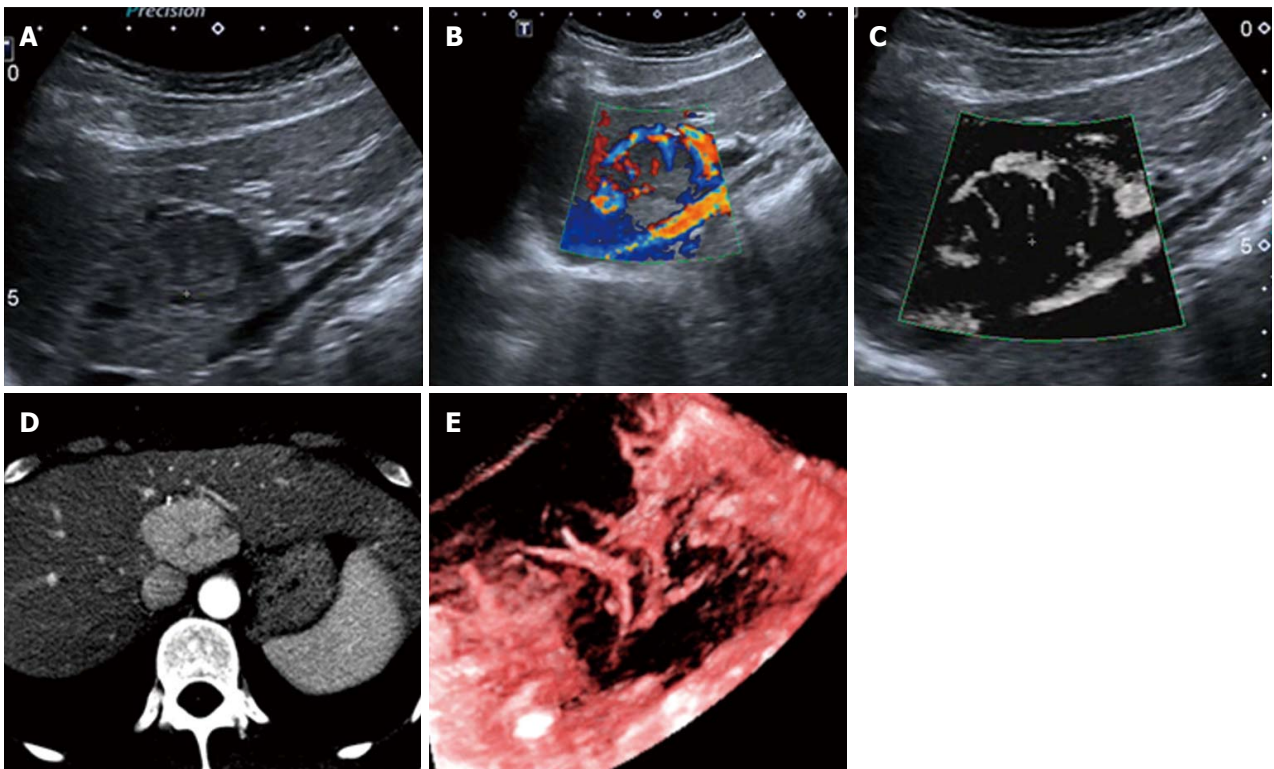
Spoke-wheel type (type VII) in a 39-year-old female diagnosed with focal nodular hyperplasia. A: A low-echo lesion with a relatively clear margin was evident in the caudate liver lobe; B: CDFI showed a spoke-wheel blood flow signal of this lesion; C: SMI showed a spoke-wheel-distributed microvascular structure; D: Contrast-enhanced CT showed diffuse enhancement with a central scar of the lesion in the arterial phase; E: 3-D vascular remodeling of this lesion was successfully achieved and showed spoke-wheel blood flow. SMI: Superb microvascular imaging.
